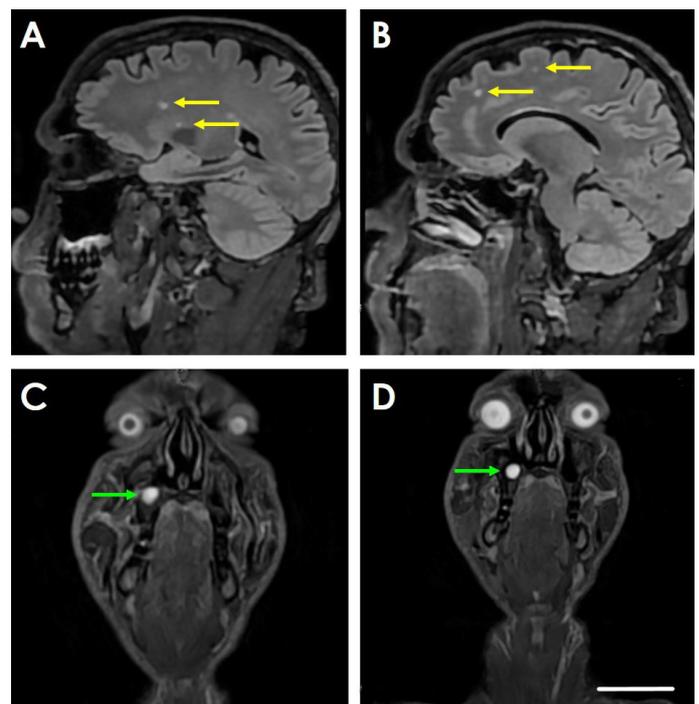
Representative photographs taken of magnetic resonance images generated with and without contrast were obtained to evaluate the results of treatment of a malignant melanoma with TOL, 5 weeks after completing the first round, 3-weekly, 2-day cycles of treatment. The analysis of T2 and FLAIR imaging of the brain in A and B, revealed areas of hyperintensity in the frontal and parietal periventricular white matter (yellow arrows) that are consistent with a history of migraine headache or previous closed head injury. The T1 and T2 axial and coronal images of the face and neck with dotarem contrast shown in C and D revealed polypoid mucosal changes in the floor of the right maxillary sinus (green arrows) that are consistent with a history of previous or chronic sinus disease. No lymphadenopathy was noted and there was no evidence of mass effect or abnormal signal intensity consistent with the previous melanoma or metastatic disease. Calibration bar in D=5 cm.
